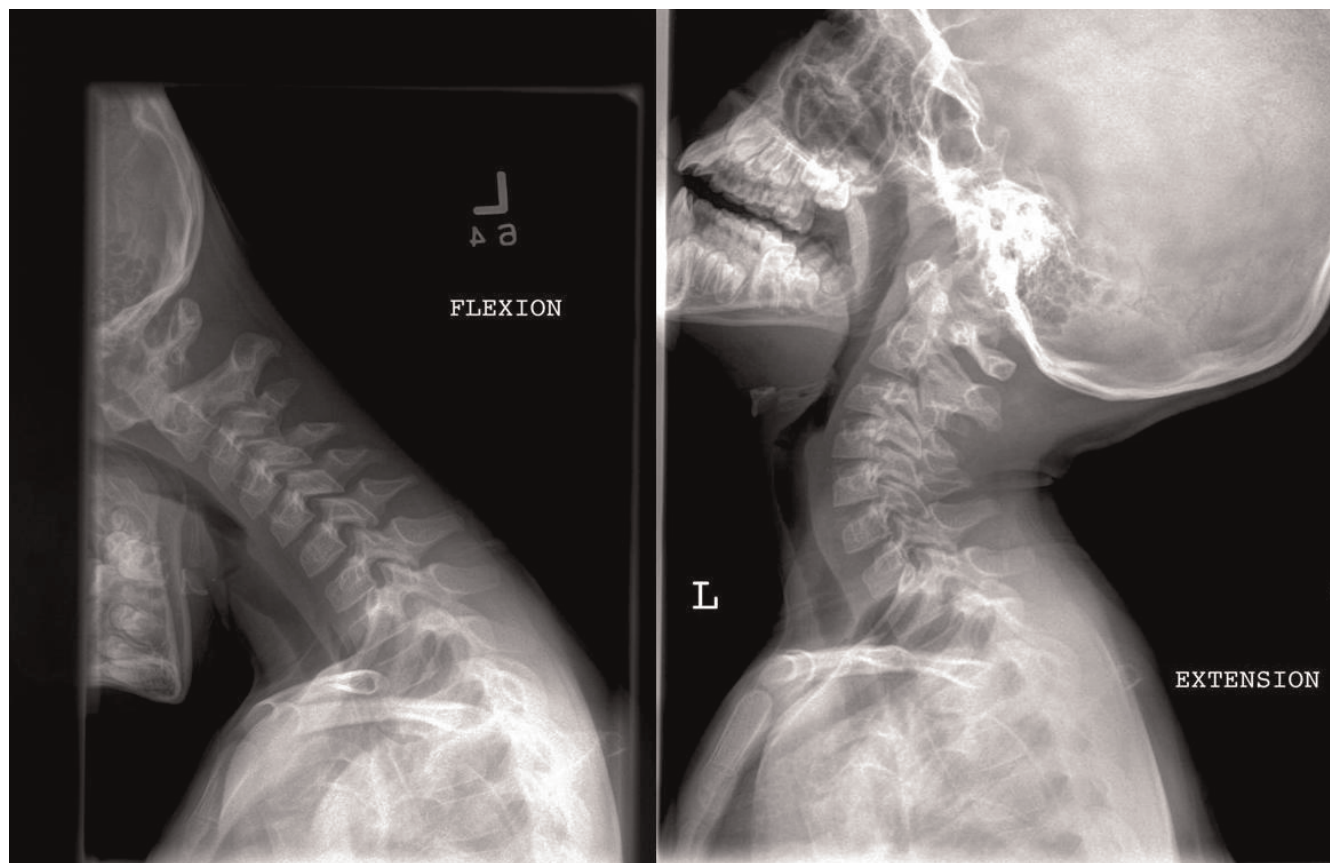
(A) Flexion and (B) extension cervical spine X-rays show an increased atlantodental interval of up to 8 mm.
